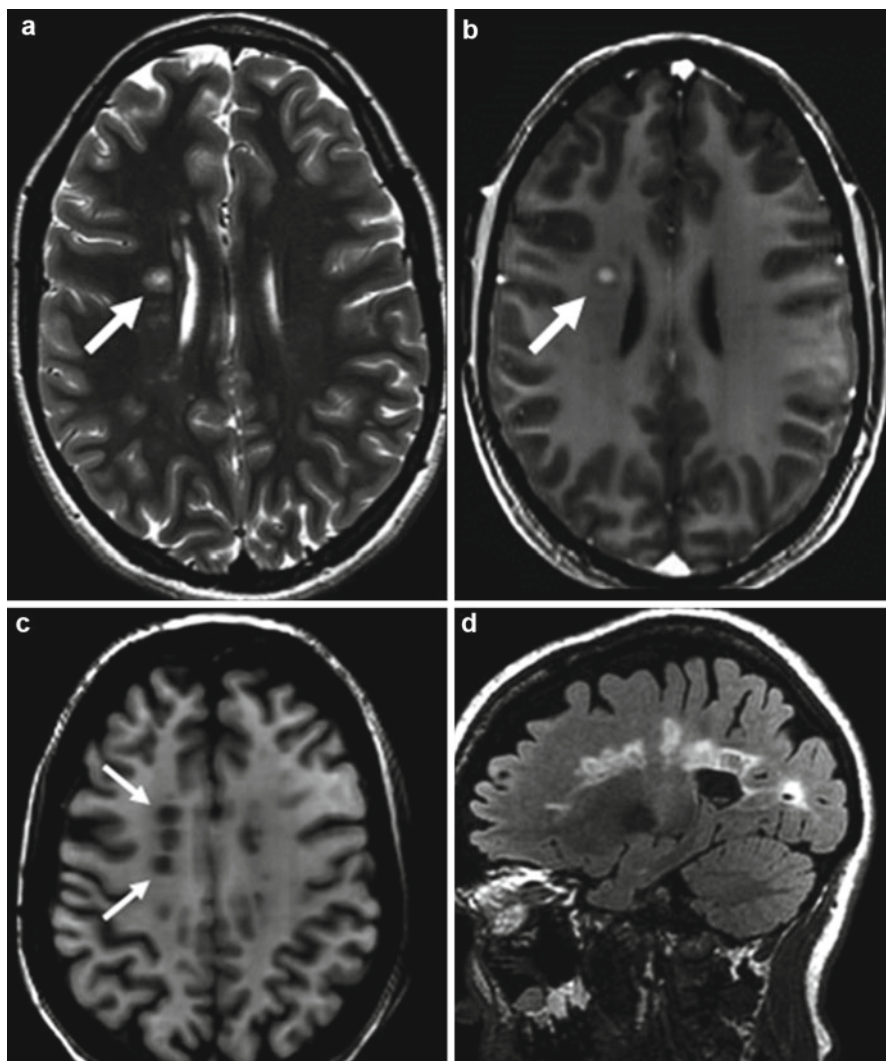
Multiple sclerosis. (a) Hyperintense lesion on T2WI that enhances on post-gadolinium T1WI (b). Enhancing lesions are indicative of active disease. (c) T1WI demonstrates multiple hypointense lesions (“black holes”) on a separate patient. T1-hypointense lesions persistent over time are indicative of irreversible axonal loss. (d) Sagittal T2 FLAIR demonstrates the characteristic “Dawson’s fingers”
